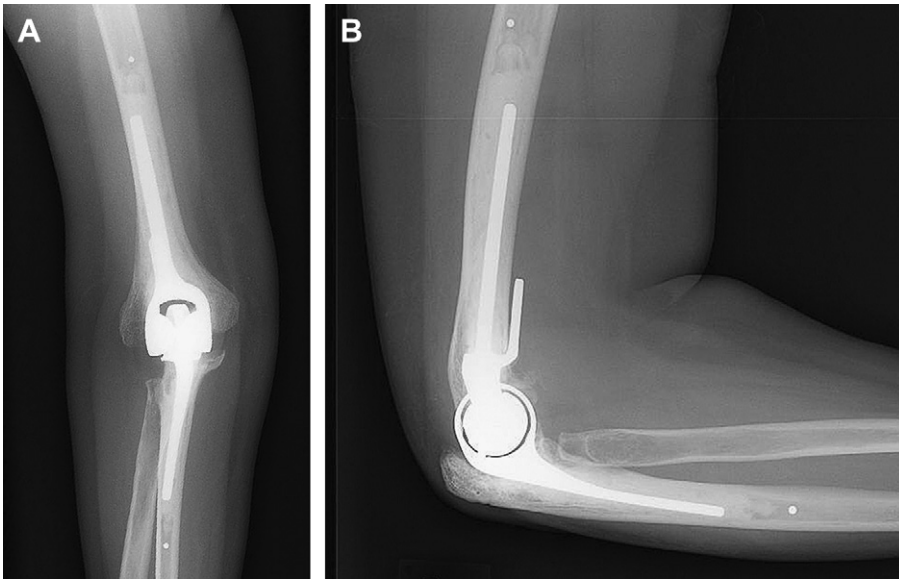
(A) Anteroposterior and (B) lateral radiographs after total elbow arthroplasty.
